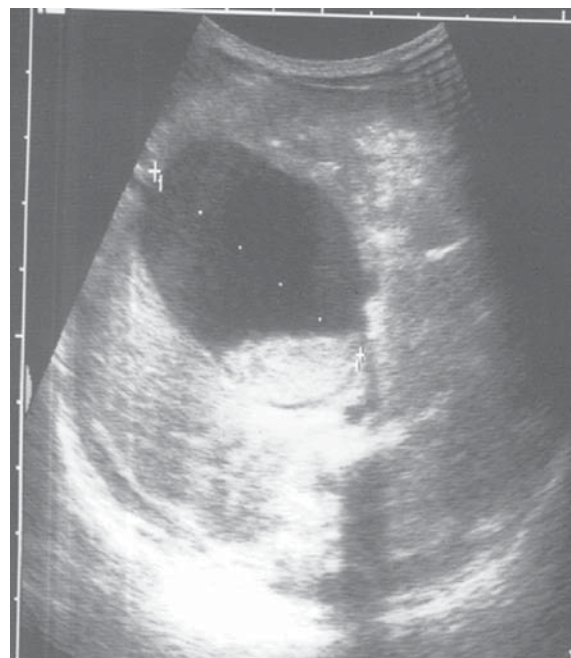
Abdominal ultrasound of choledochal cyst.
